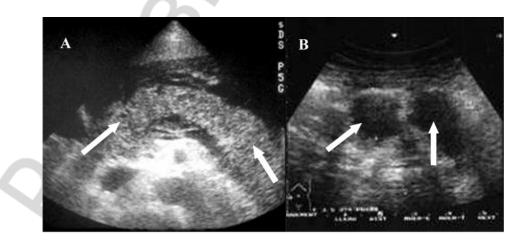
Ultrasound in acute pancreatitis:
